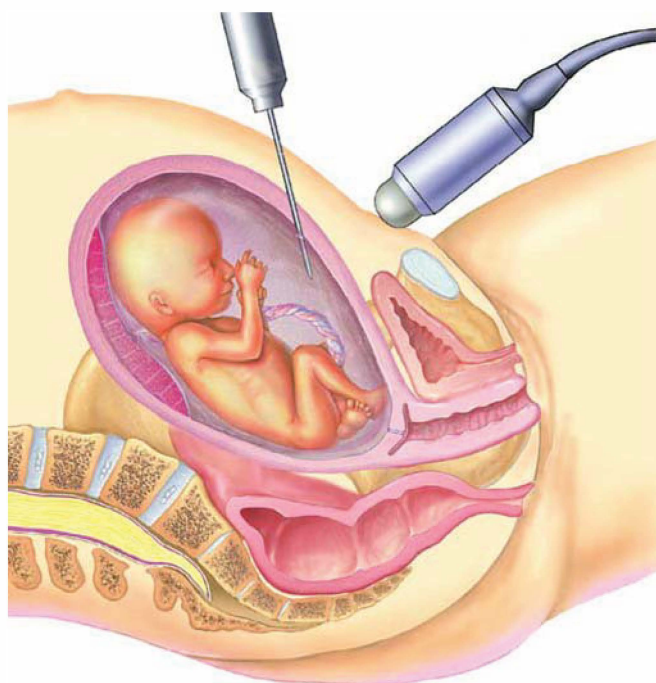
Amniocentesis is performed under ultrasound guidance. A needle is inserted through the mother's abdomen into a pocket of amniotic fluid, which is then aspirated with a syringe.
